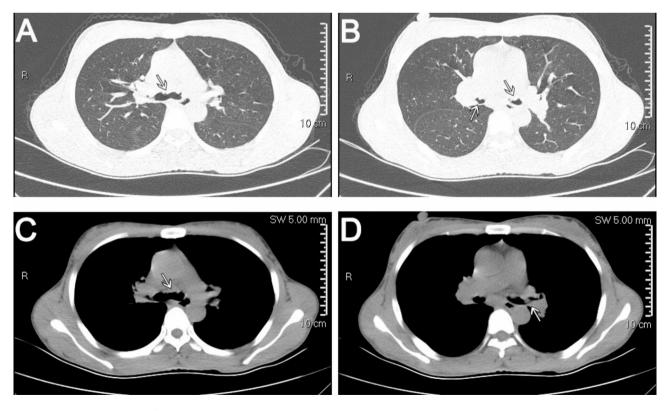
Computed tomography of the chest. A-D: Chest CT showed tracheal and bronchial lesions. (A, B: lung window; C, D: mediastinal window)
